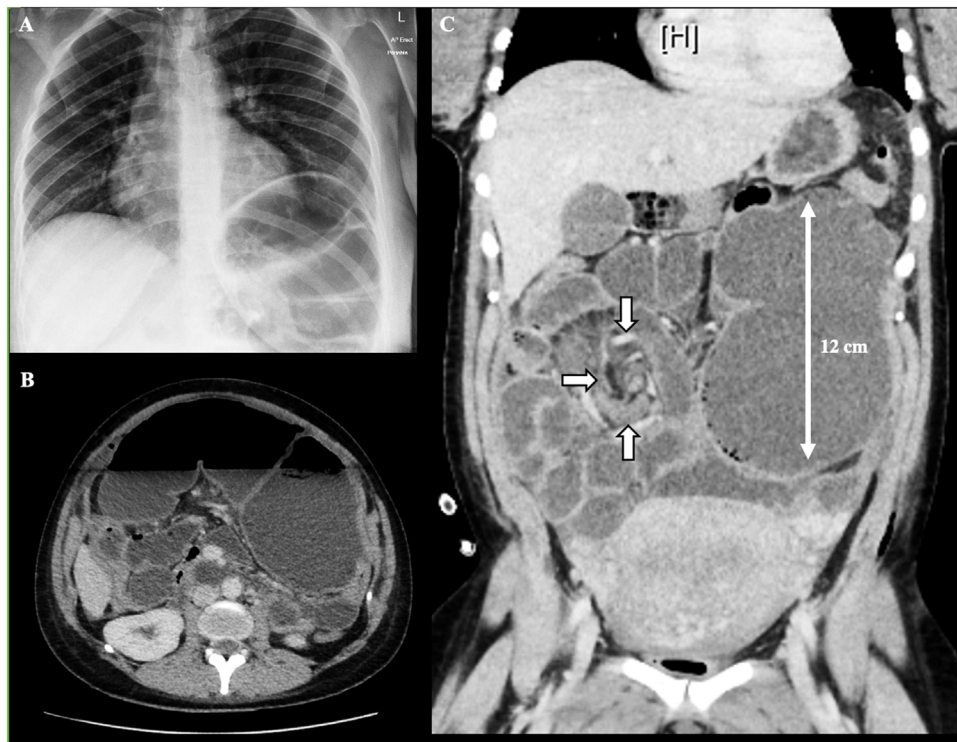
Erect chest x-ray on admission [A]. Axial [B] and Coronal [C] views, of computerised tomography (CT) of the abdomen and pelvis with contrast. CT demonstrated gross distension of caecum and proximal colon; with associated mesenteric twisting suggestive of caecal volvulus (12 cm). Note the associated 'whirl sign' marked out by three white arrows in Figure C.
